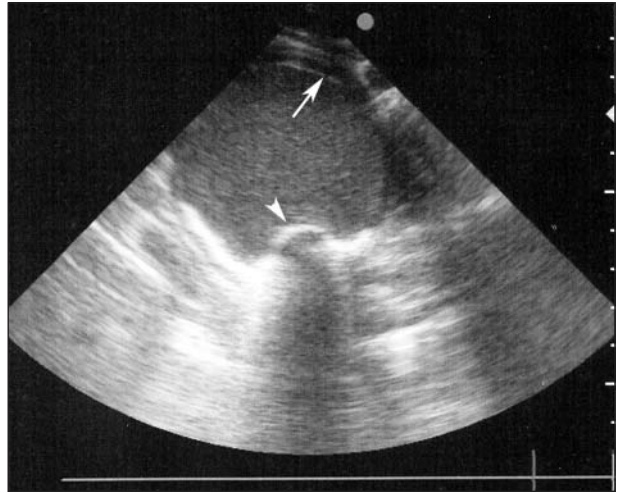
Transverse ultrasonographic image of the cranial portion of the esophagus obtained with a 5.0-MHz sector scanner. Notice the homoechogenic, well-encapsulated (arrow) structure associated with the esophagus and the position of a nasogastric tube within the esophageal lumen (arrowhead).
